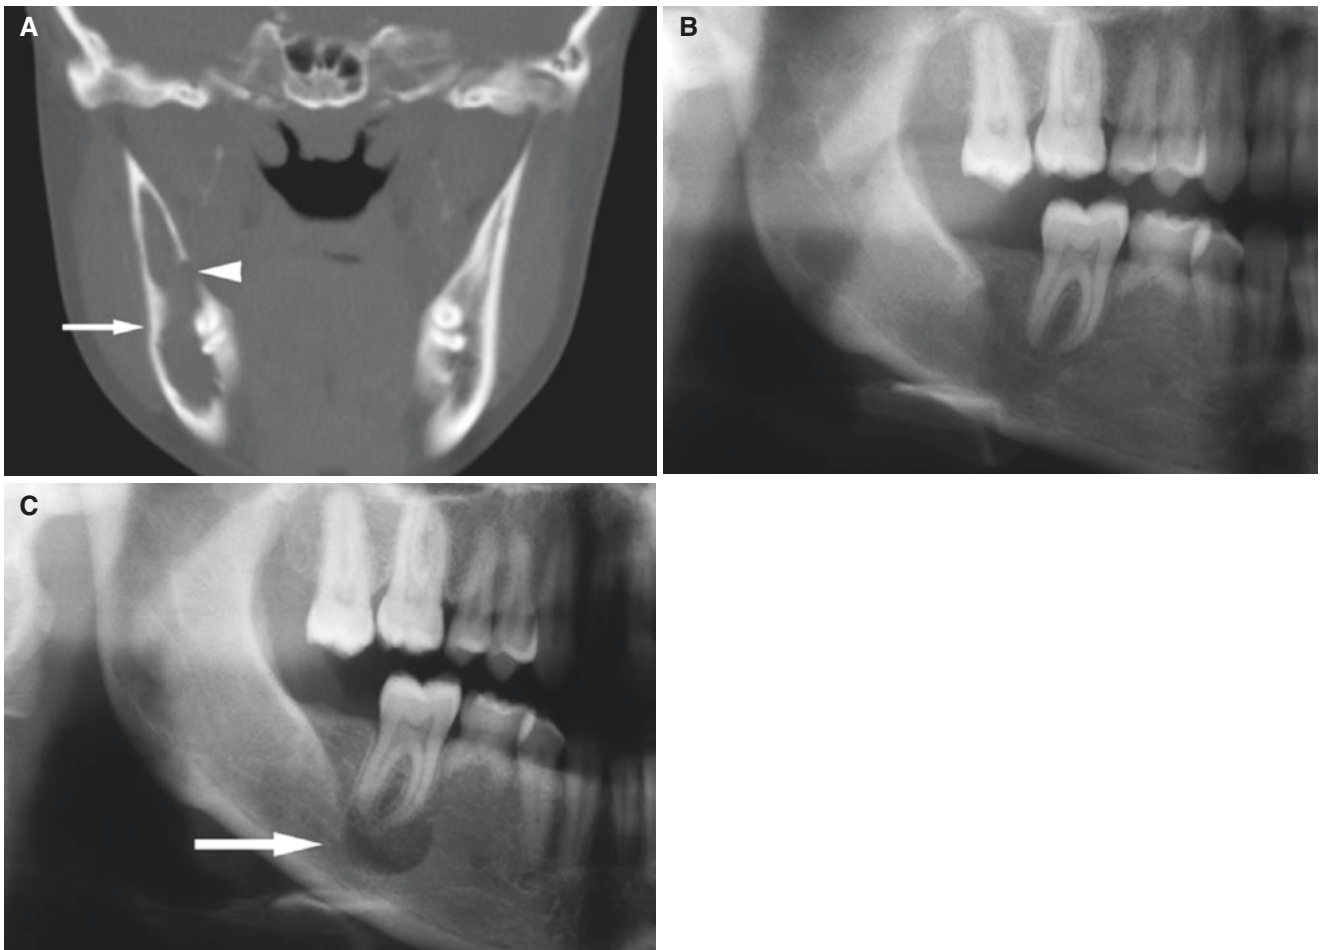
Keratocystic odontogenic tumor, mandible; 19-year-old female with incidental finding at routine dental radiography, followed for 6 years, never symptomatic. (A) Coronal CT image shows radiolucency
